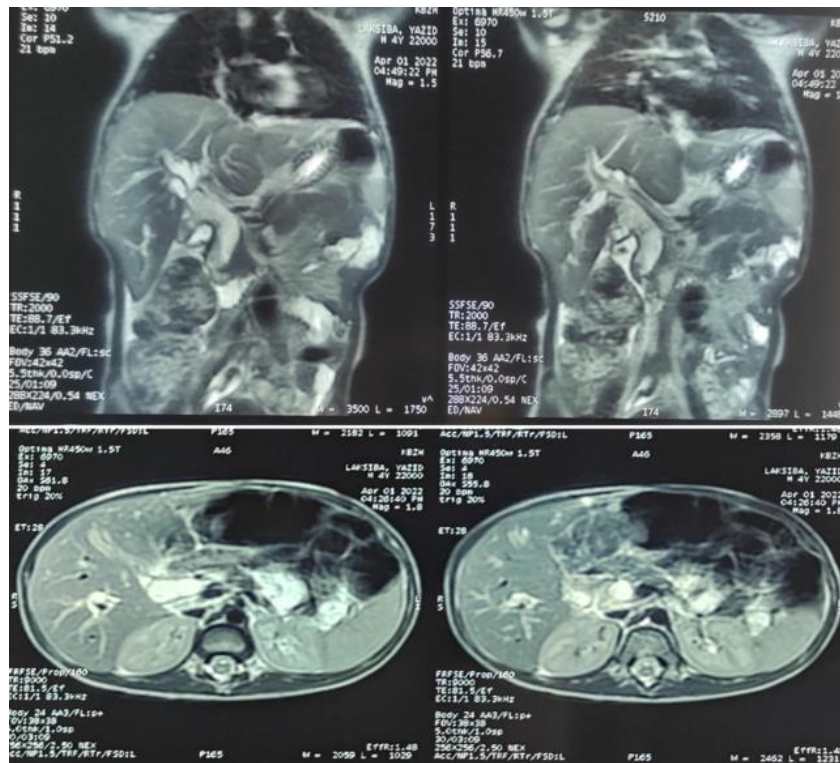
Initial MRI in T2 sequence after injection of gadolinium: Filling of the bile duct lumen by heterogeneous material enhanced by gadolinium with dilatation of the bile ducts
